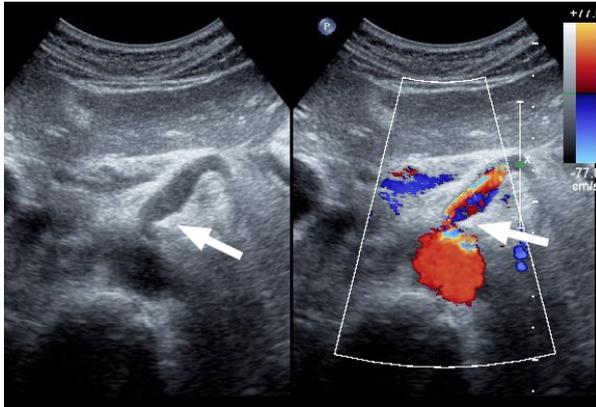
Hooked shaped stenosis (arrows) of the coeliac trunk in colour duplex sonography.
